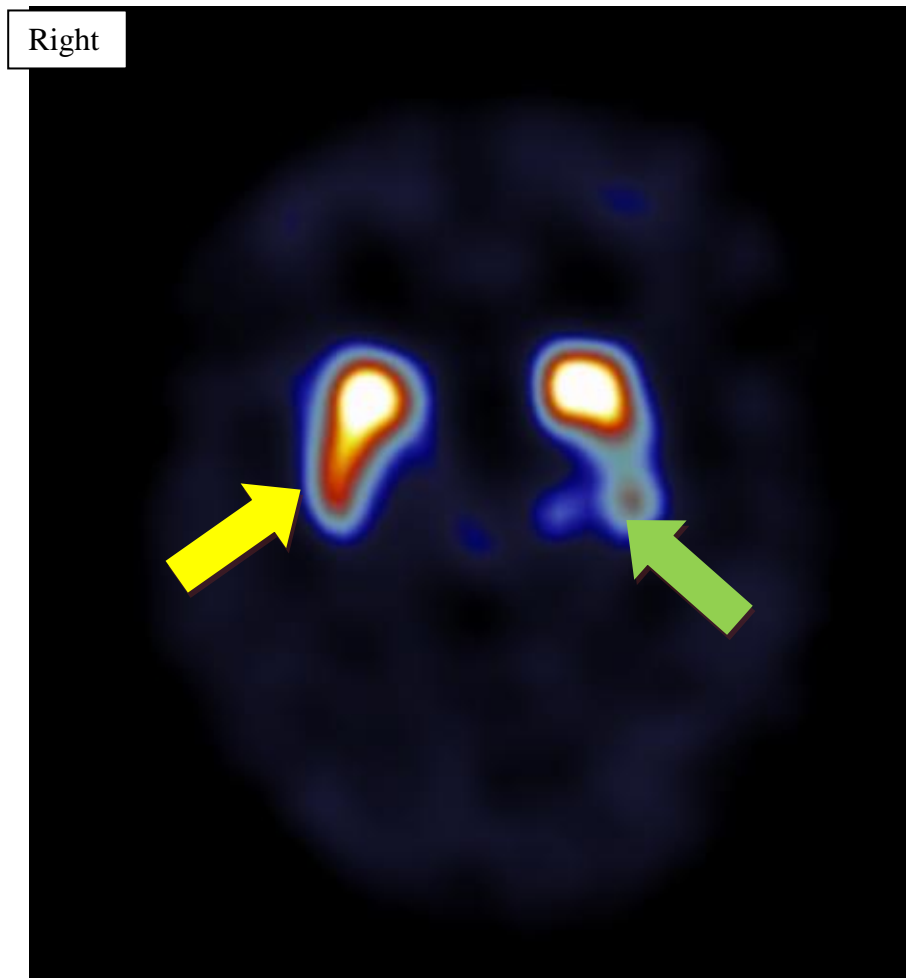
Image from abnormal FP-CIT SPECT scan demonstrating reduced, asymmetrical radiotracer uptake within the putamen, most evident on the patient's left side (green arrow), but also showing early reduction on the patient's right side (yellow arrow).
